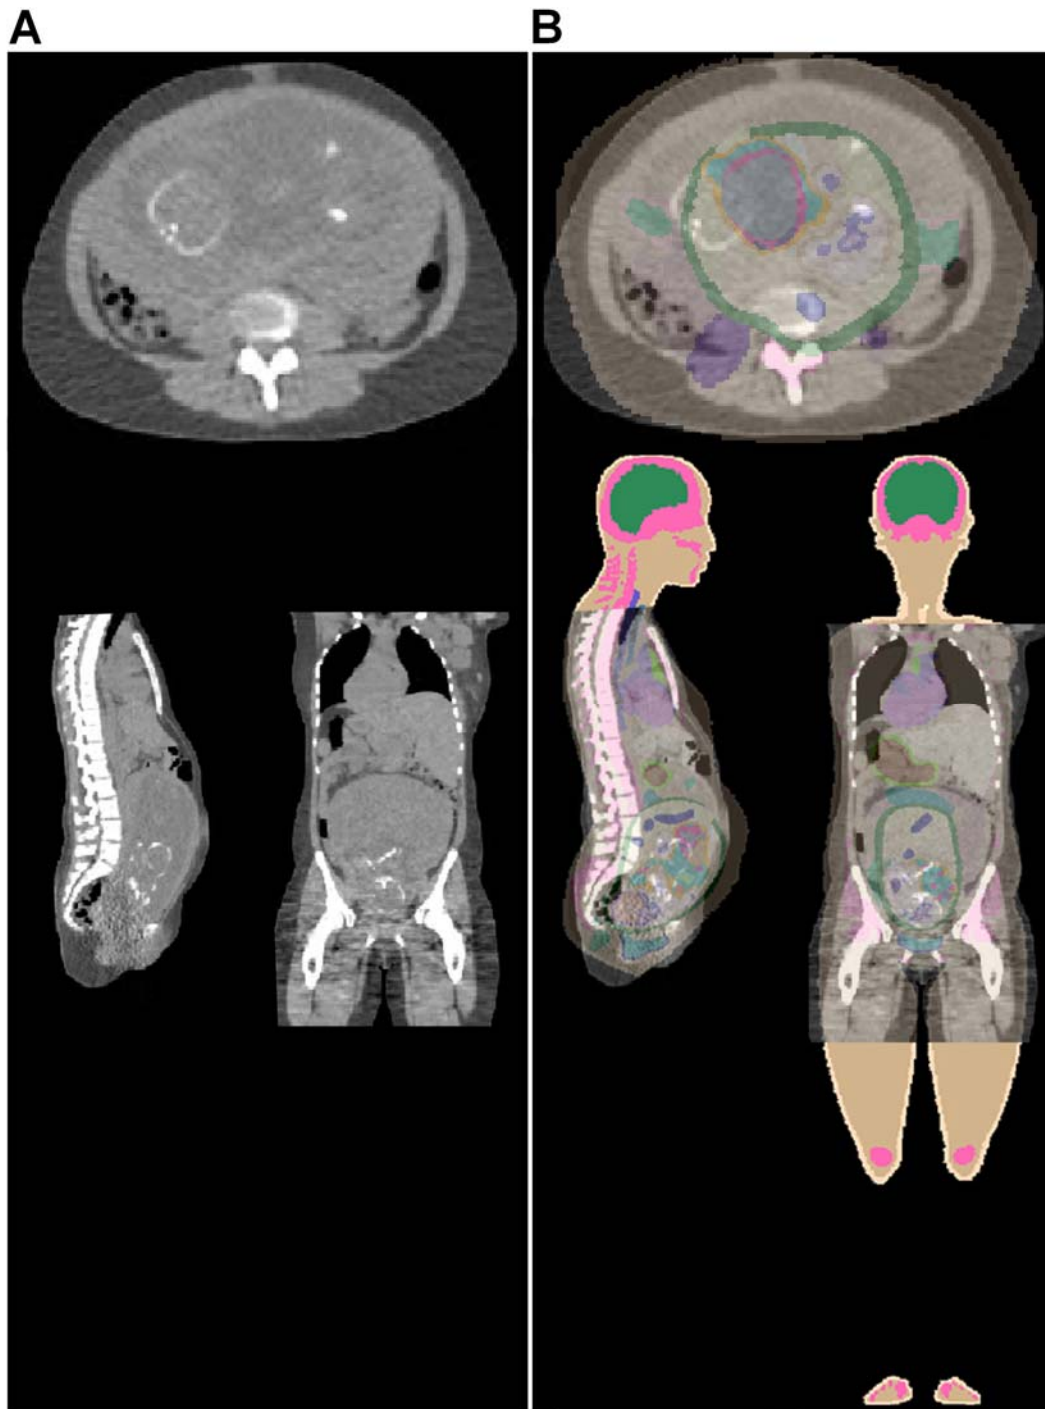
(A) CT image with external body contour (red line) around the perimeter of the pregnant patient and the uterus (blue line) containing 25-week-old twin fetuses. (B) Segmented CT image with external body contour, skeleton and uterus.
